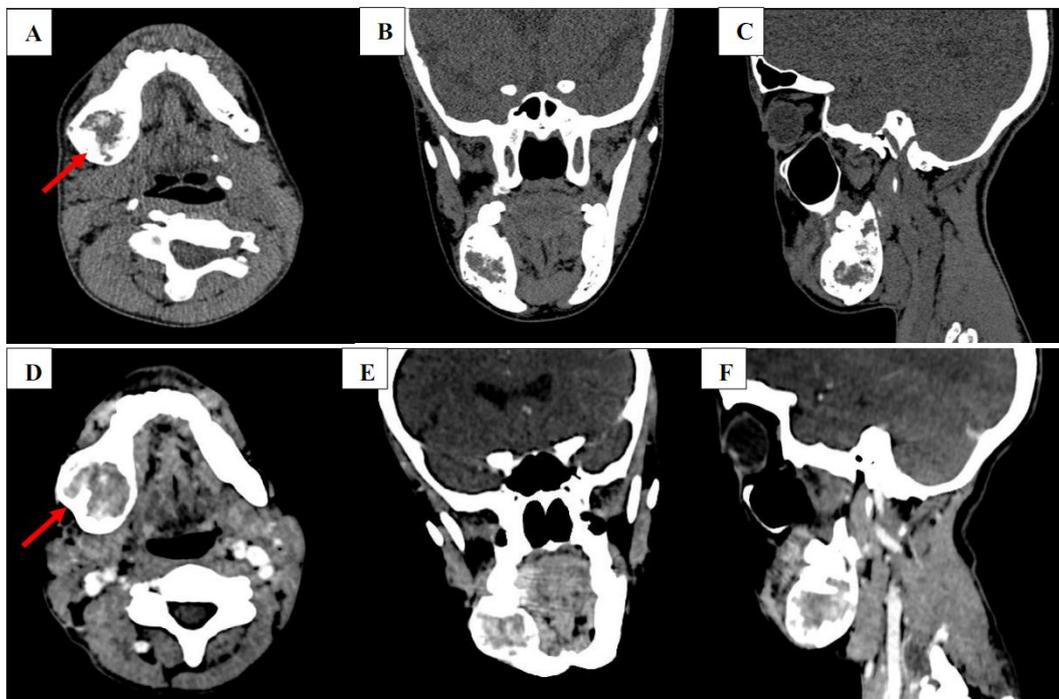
Non-contrast axial (A), coronal (B) and sagittal (C) CT images in parenchymal window showing a solitary expansile osteolytic tissue mass centered on the right body of the mandible and extended to the homolateral angle. Post-contrast axial (D), coronal (E) and sagittal (F) CT images showing heterogeneous enhancement of the lesion
